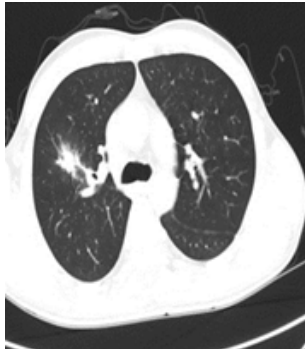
Lung CT on admission.
